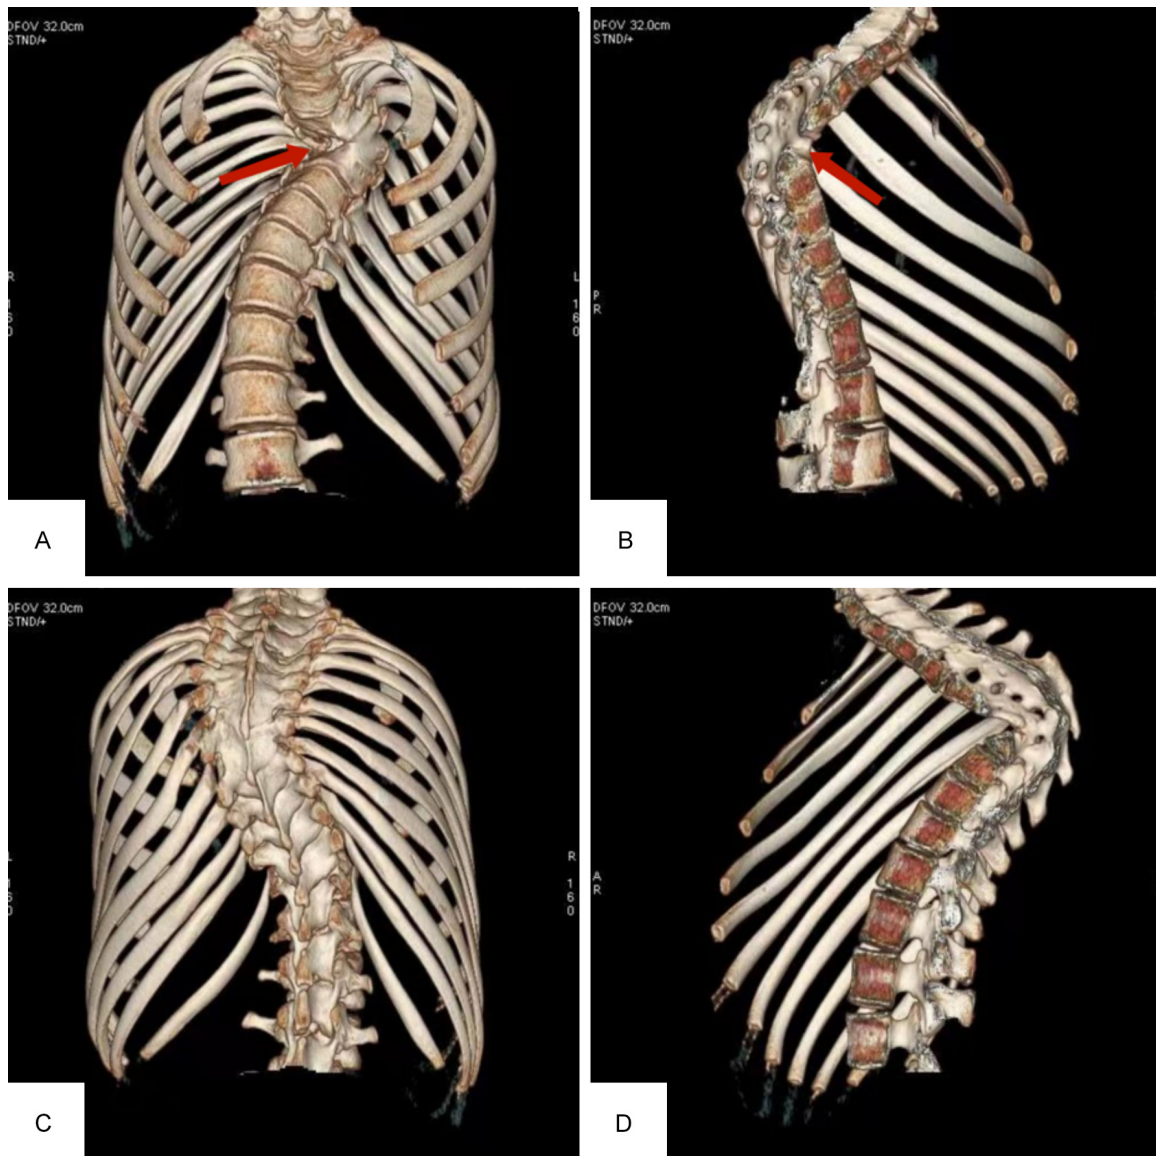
Three-dimensional CT revealed that the thoracic scoliosis was deformed with angled kyphosis; the T7 anterior vertebral body spina bifida (red arrow. A/B); the T4-T8 vertebral body morphology was abnormal, the intervertebral space fusion disappeared (C), and the spinal canal was unevenly expanded (D).
